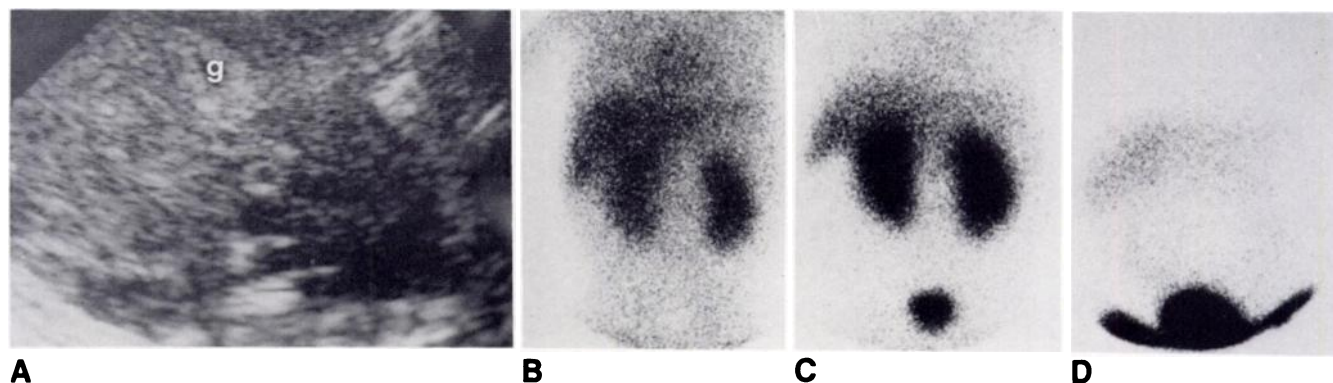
Neonatal hepatitis with severe hepatocellular damage in 9-week-old boy. A, Longitudinal sonogram. Small gallbladder (g). Hepatobiliary scintigrams at 5 min (B), 1 hr (C), and 6 hr (D). Liver activity is only slightly greater
